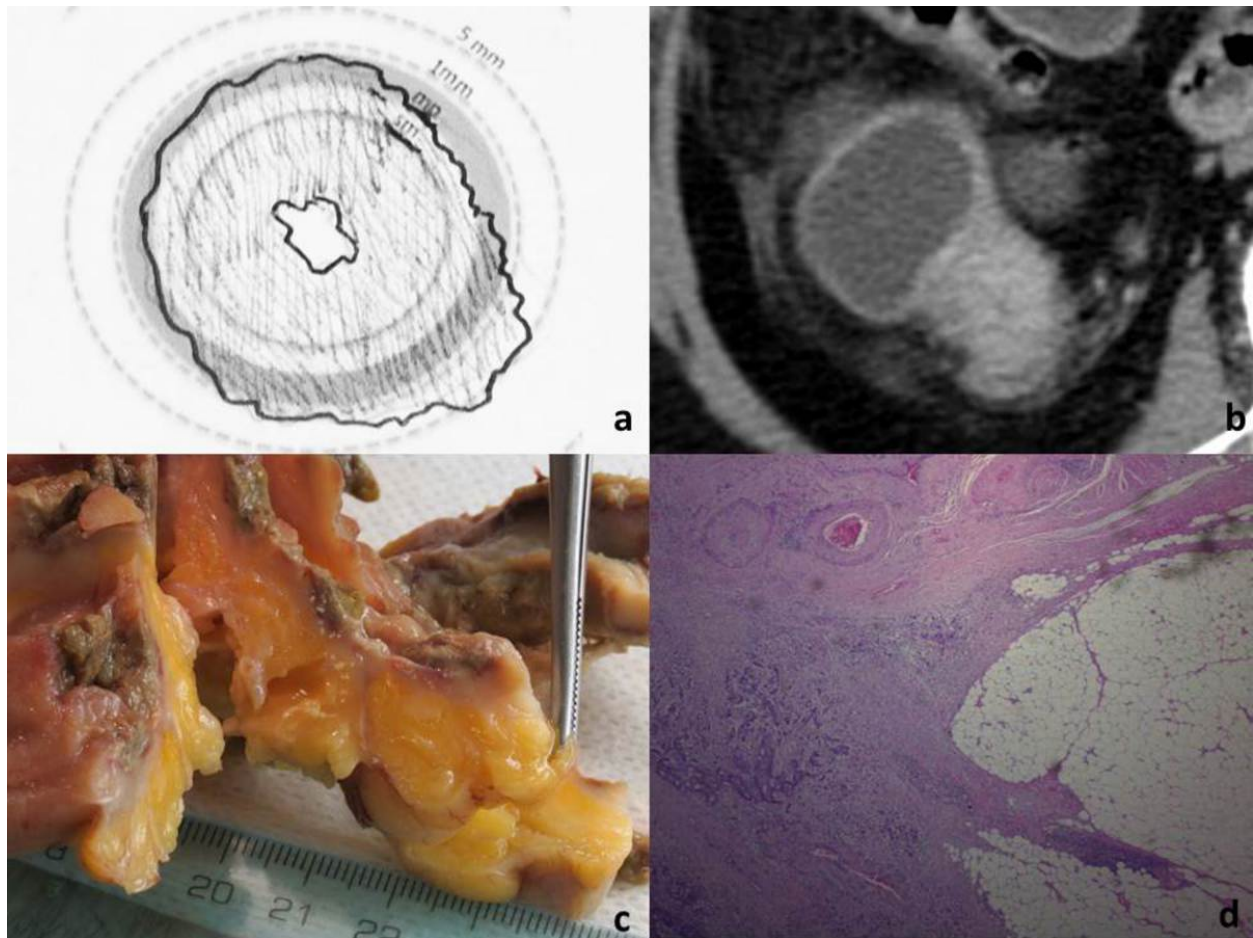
Example of the local staging section. The radiologist examines the CT and makes a graphic representation of the tumour, showing the deepest infiltration of the colon wall. The circular lines on the graphic represent the mucosal layer and the muscularis propria. An additional line corresponding to 5mm distance from the muscularis is also represented. In the case shown, the tumour was staged as a T3 with less than 5mm invasion beyond the muscularis propria, and thus, as a NLACC.
